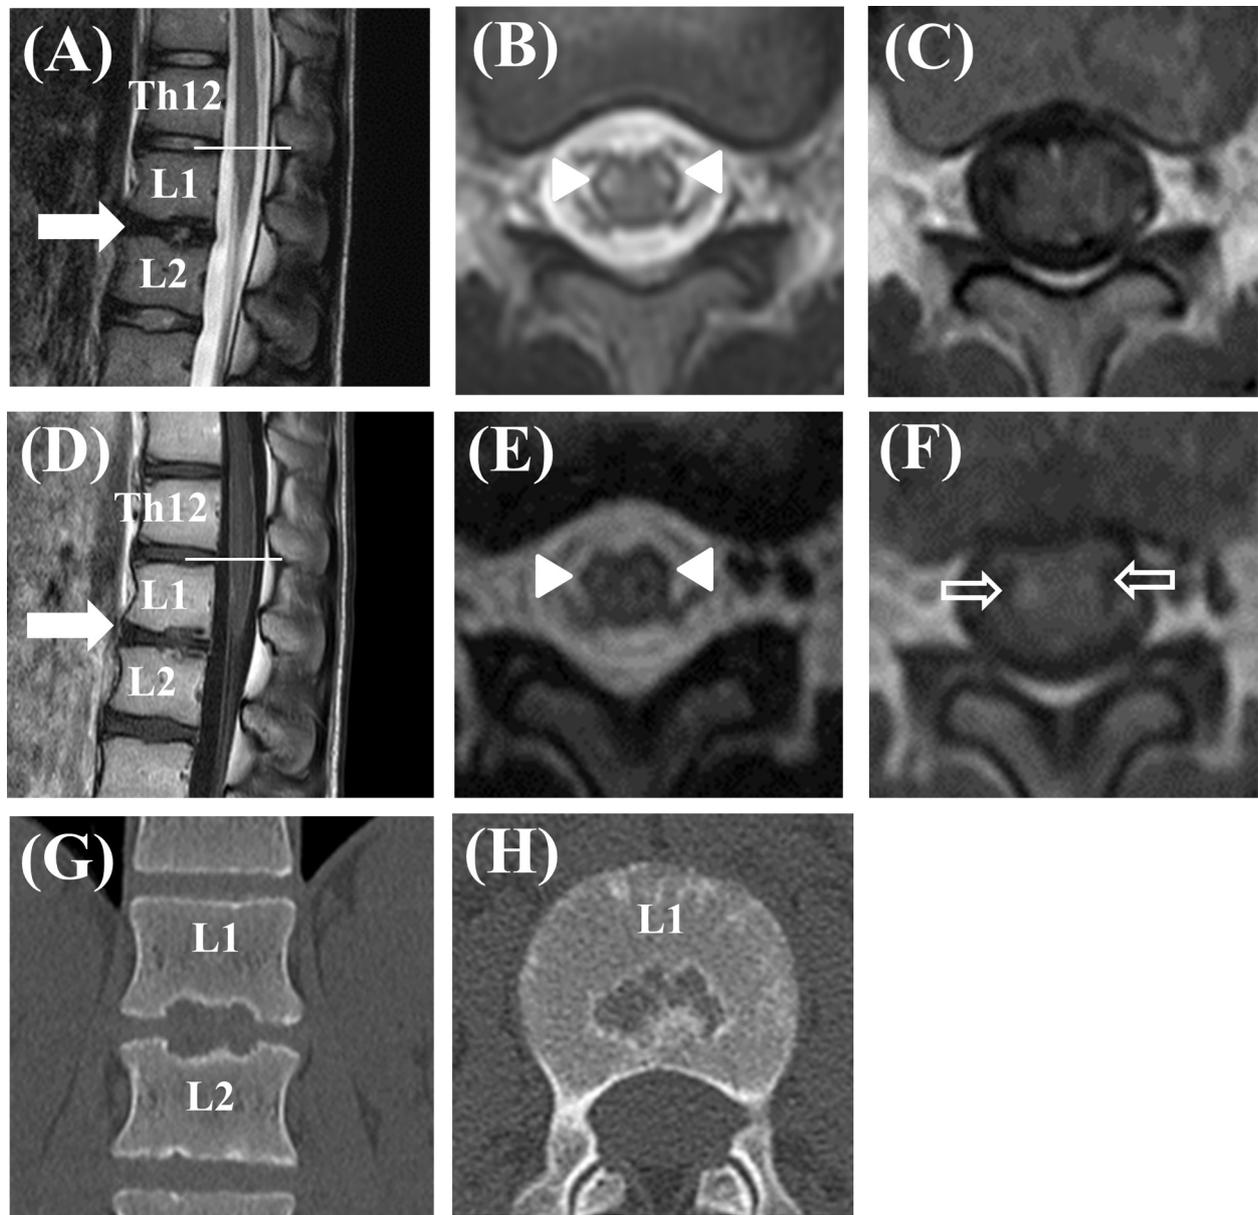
Sagittal (A), axial T2-weighted (B), and contrast-enhanced (C) images of the lumbar spinal cord on day 1. The sagittal and contrast-enhanced images of Th12/L1 showed no abnormalities. The axial T2-weighted image showed an increased signal bilaterally at the Th12/L1 level in the anterior horn of the spinal cord (B) (arrowhead). The sagittal image revealed no abnormality on day 13 (D). However, a high-intensity area of the axial T2-weighted image at Th12/L1 appeared diminished (E) (arrowhead), and new findings were noted on a contrast-enhanced image at Th12/L1 (F) (the right side is more strongly enhanced than the left side; empty white arrow). In addition, L1/L2 disk collapse and Schmorl node (white arrow) (A and D) were observed, along with adjacent vertebral end-plate destruction on computed tomography (G and H).
